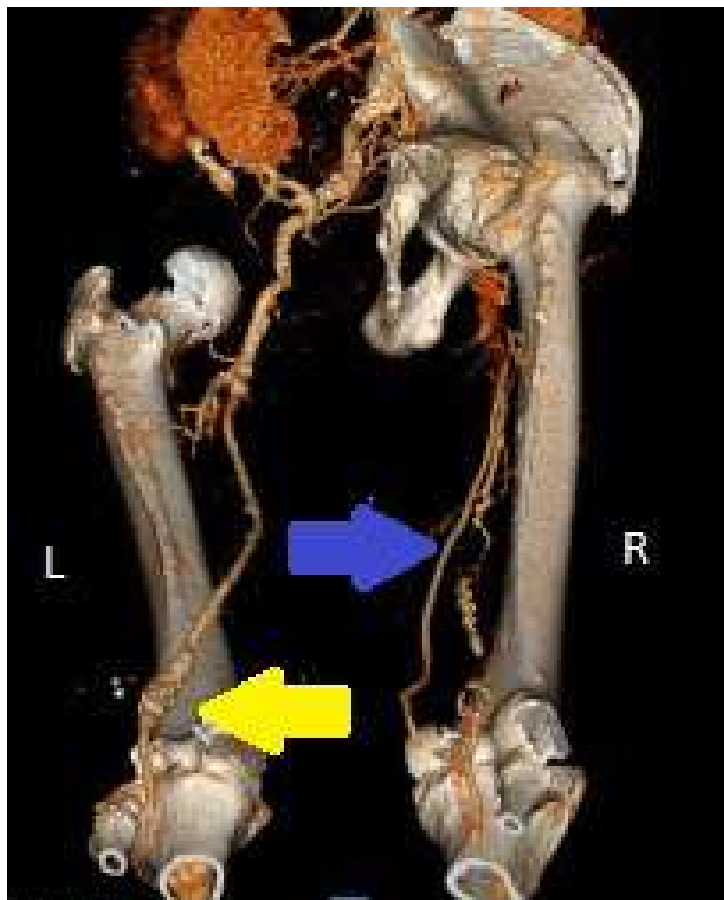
30d postoperative follow-up CTA in 3D reconstruction, showing a patent venous fem-pop bypass graft (right, blue arrow) and the contralateral popliteal artery aneurysm (pink arrow) scheduled for elective endovascular treatment.
